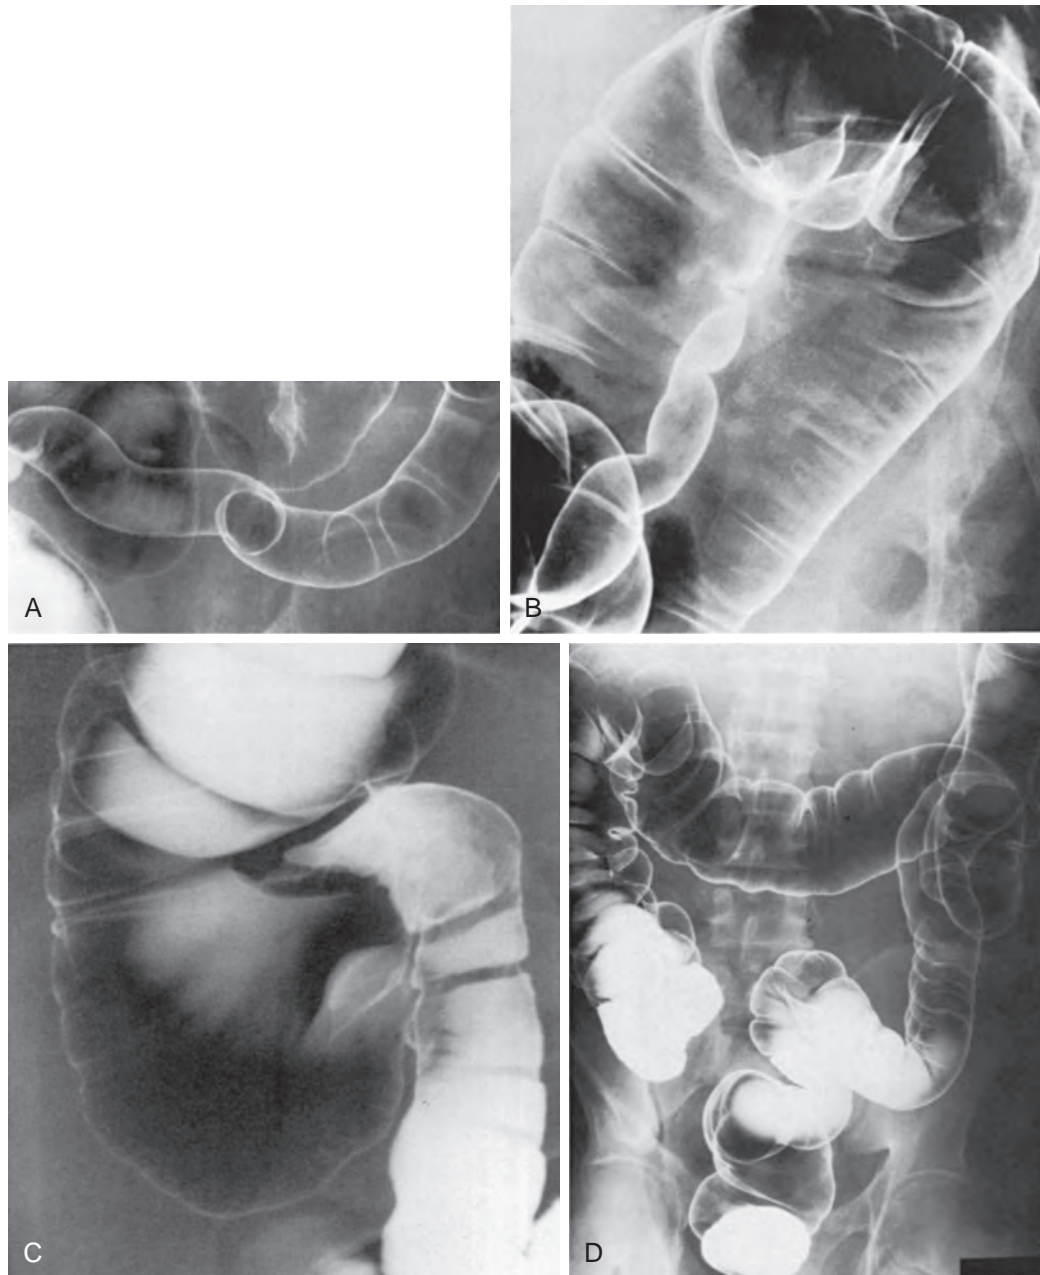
Selected radiographs from normal examinations. A. Spot radiograph of the sigmoid colon in the left posterior oblique position. B. Upright spot radiograph of the splenic flexure in the right posterior oblique position. C. Spot radiograph of the cecum and terminal ileum in the supine position. D. Overhead radiograph in the prone position.
